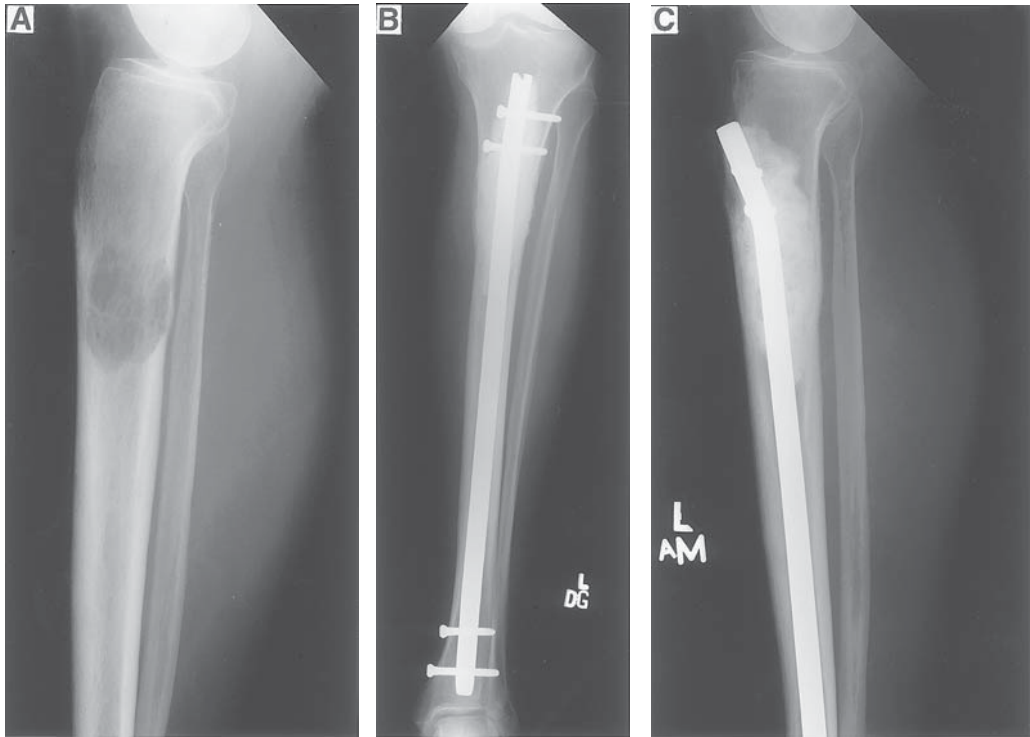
(A) Lytic lesion in a 59-yr-old male proximal tibial shaft. (B) and (C) Asymptomatic patient with radiographs at 9 mo postoperatively. Patient received 3000 cgy 4 wk postoperatively.
